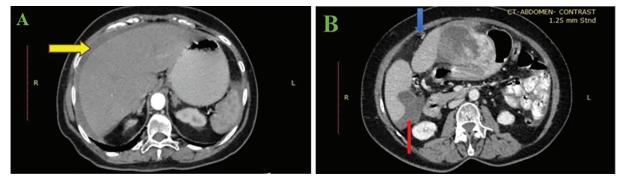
A. Abdomen Axial view in Contrast Enhanced Computed Tomography shows hemoperitoneum (yellow arrow). B. Pedunculated mass with claw sign (blue arrow), hemoperitoneum (red arrow).
